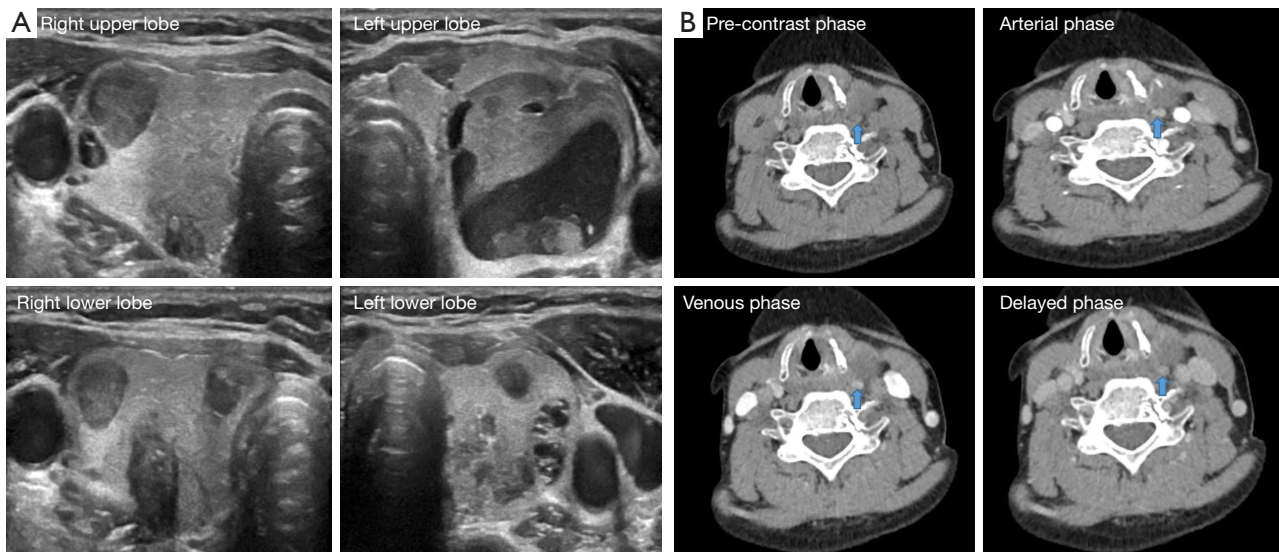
A representative case where localization was unattainable with US (A) but was successfully identified using 4D CT (B). Images of a 55-year-old woman with left superior parathyroid adenoma. (A) Due to the multinodular goiter, localization of abnormal parathyroid lesions using US was difficult. (B) 4D CT showing a parathyroid lesion (arrow) with type A enhancement characteristics. The lesion exhibits low attenuation during the pre-contrast phase and hyperattenuation during the arterial phase, after which the delayed-phase image shows a washout of contrast material with decreasing attenuation compared to the arterial phase. 4D CT, four-dimensional computed tomography; US, ultrasonography.
